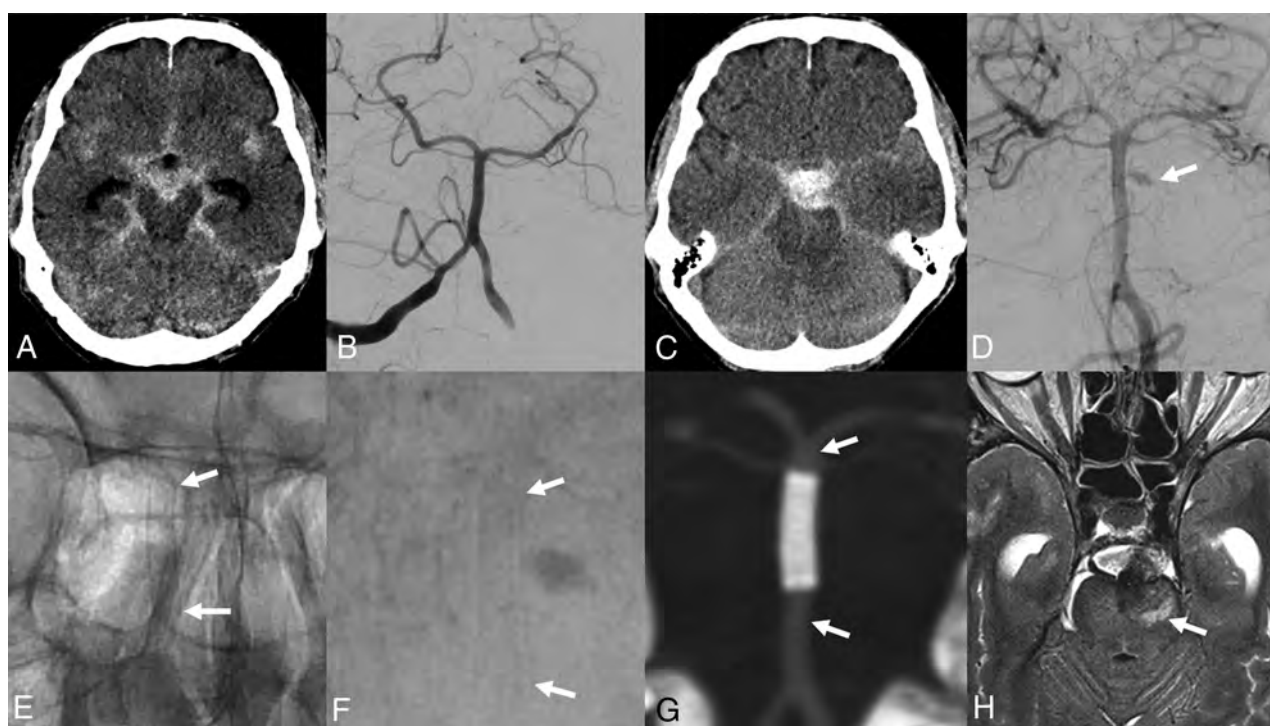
A, NCCT depicts an acute basal SAH. B, DSA on the day of the SAH shows no aneurysm. C, SAH rebleeding on day 5 after the initial bleed. D, NCCT now demonstrates an unusual aneurysm interpreted as a dissecting aneurysm of a basilar artery perforator (arrow). E, Treatment of the aneurysm with a hydrophilic-coated flow diverter; unsubtracted image right after deployment (arrows indicate the ends of the flow diverter). F, Subtracted image from the treatment. Slow filling of the aneurysm can be still seen (late arterial phase, arrows at the ends of the flow diverter). G, Five days after the treatment, CTA demonstrates that the flow diverter is patent (arrows). H, T2-weighted axial MR imaging 11 days after treatment. A small infarction in the territory of the aneurysm carrying the perforator can be seen (arrow). No infarcts due to the flow diverter are noted (this is patient 5, Online Supplemental Data).
